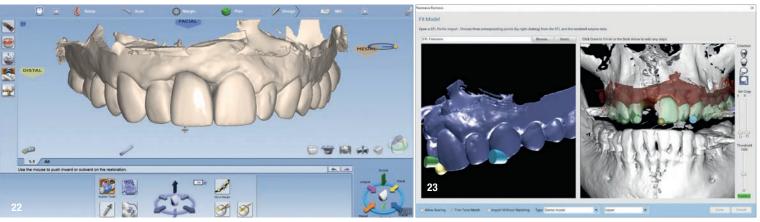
Mirror contralateral tooth feature. Fig. 23: Software best algorithm alignment using the 3 common points of the intraoral impression STL and CBCT scan.
